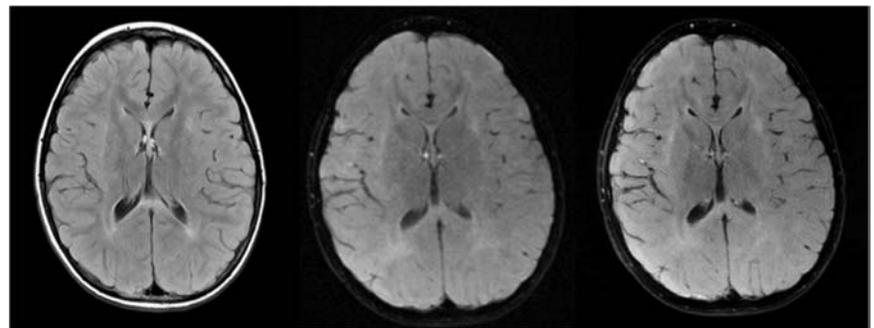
Comparing the FLAIR FSE, EPI-FLAIR, and rs-EPI-FLAIR images acquired on a 6-year old patient. Note the right-edge artifact on the rs-EPI is an unexplained issue with the reconstruction.
